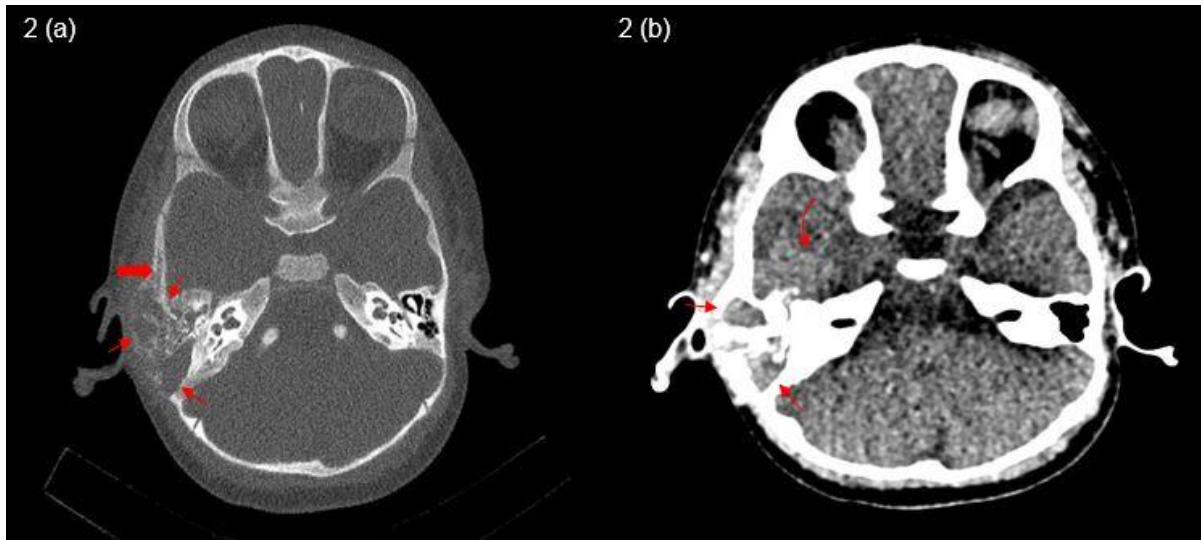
Non-contrasted bone (2a) & soft tissue window (2b) images of temporal bone CT scan show expansile bony lytic destructive lesion with soft tissue component within (thin red arrow) involving the mastoid portion of right temporal bone with periosteal reaction (thick red arrow) and intracranial extension (curved red arrow) into regional temporal lobe.
